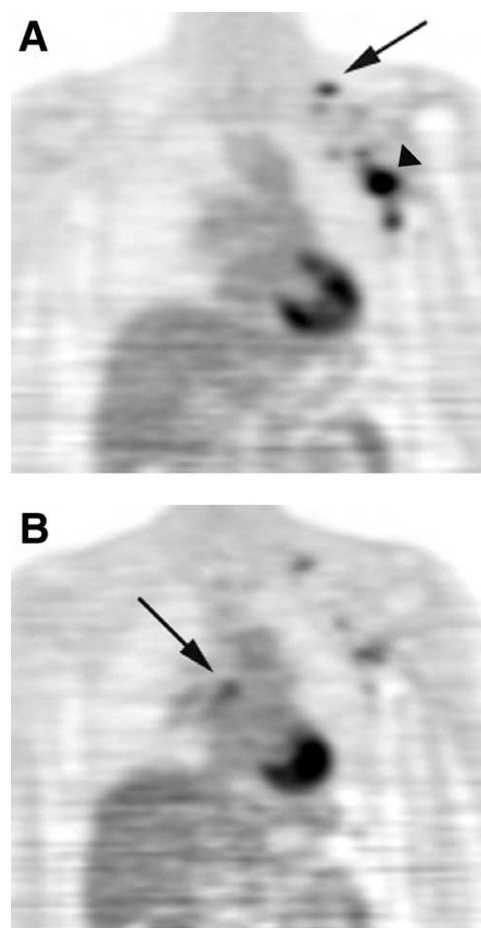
A 57-year-old woman with second left axillary recurrence 6 years after modified radical mastectomy. She was being considered for aggressive local therapy (surgery and radiation). Conventional imaging was negative for distant metastases. Coronal FDG PET image (A) shows uptake in the left axilla consistent with disease recurrence (solid arrow; SUV = 14.7), but also uptake in the left supraclavicular region (open arrow; SUV = 4.4). A more posterior coronal image (B) shows uptake in the right hilum (SUV = 5.9). Patient was treated with systemic chemotherapy rather than local therapy due to the widespread foci of suspected disease; follow-up imaging confirmed disease at PET-positive sites.
